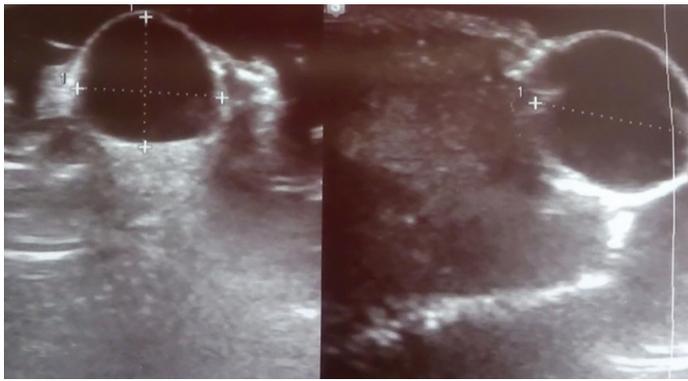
Ultrasound of parameatal cyst. An isoechoic cystic lesion anterior to the urethral orifice
